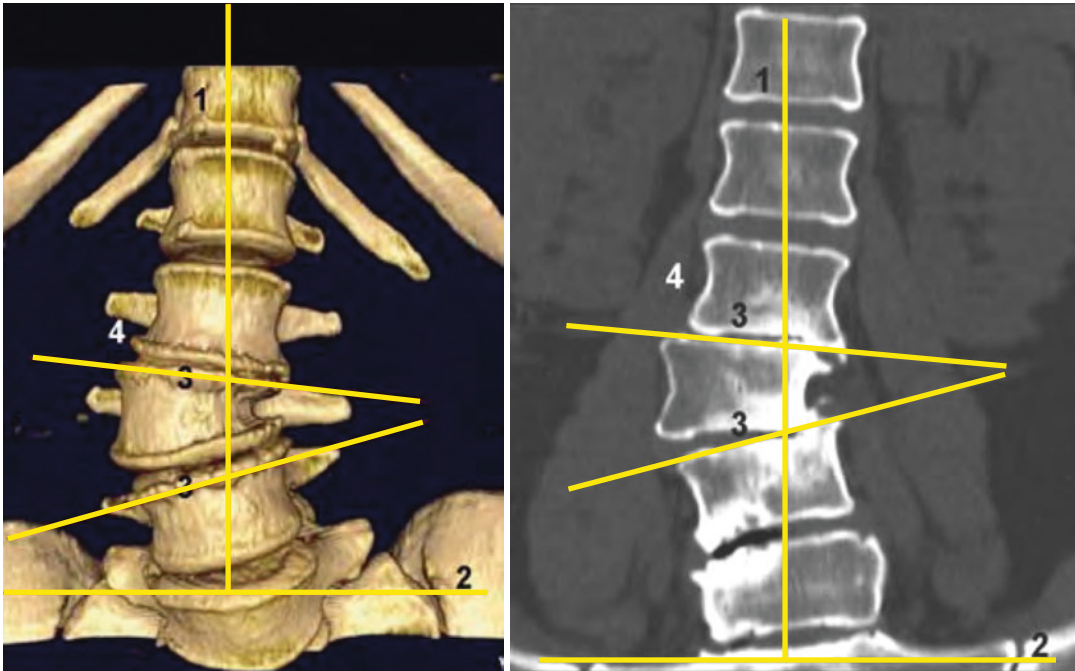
Endplate obliquity: In adult degenerative scoliosis, the measurement of the Cobb angle becomes less useful. Instead, the vertebral endplate obliquity in reference to the horizontal can be measured. A line is drawn across the superior vertebral endplates, and the angle formed with the horizontal can be used to determine the severity of scoliosis. This can be replicated on subsequent radiographs to assess for any disease progression
